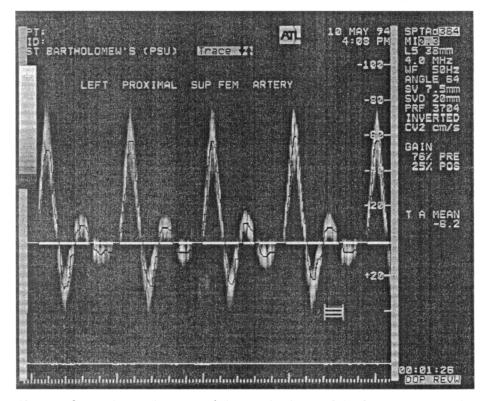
Spectral Doppler trace of the proximal superficial femoral artery, with time in seconds on the x-axis and velocity in cm/s on the y-axis. The waveform is quadriphasic with forward flow in systole, followed by reverse flow in early diastole, a small forward flow component in mid-diastole and finally a small reverse flow component in late diastole.
